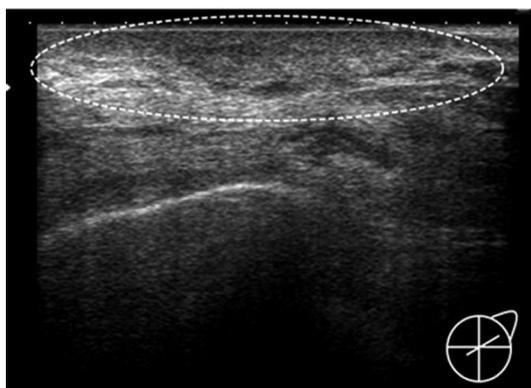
Ultrasound findings in the secondary lesion.
